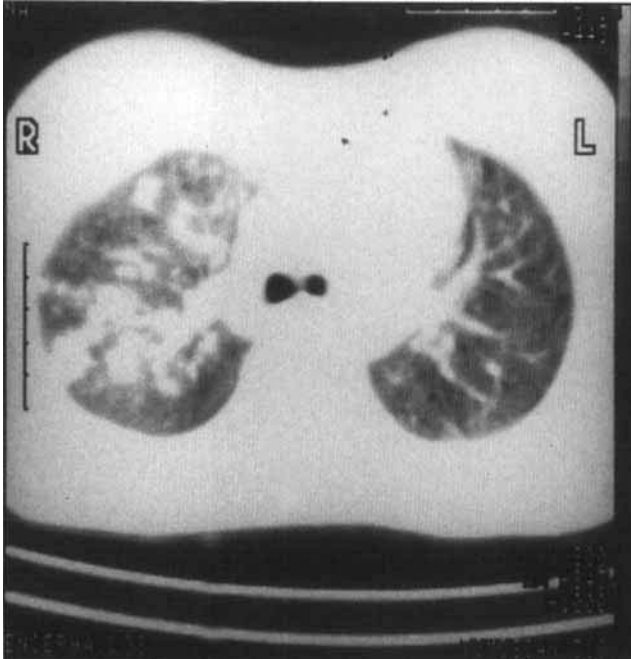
Thorax CT scan showing multiple nodular lesions in both lungs.
